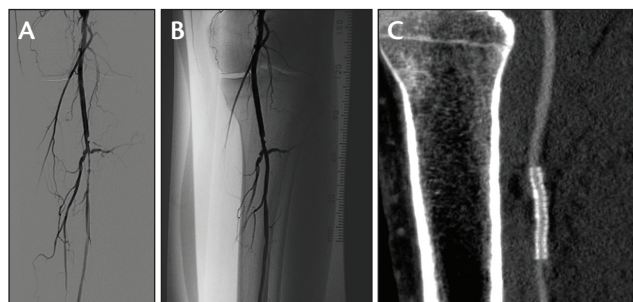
Stenosis of peroneal artery in a patient with CLI (A). Results after DES implantation (B). CTA at 6-month follow-up (C).
